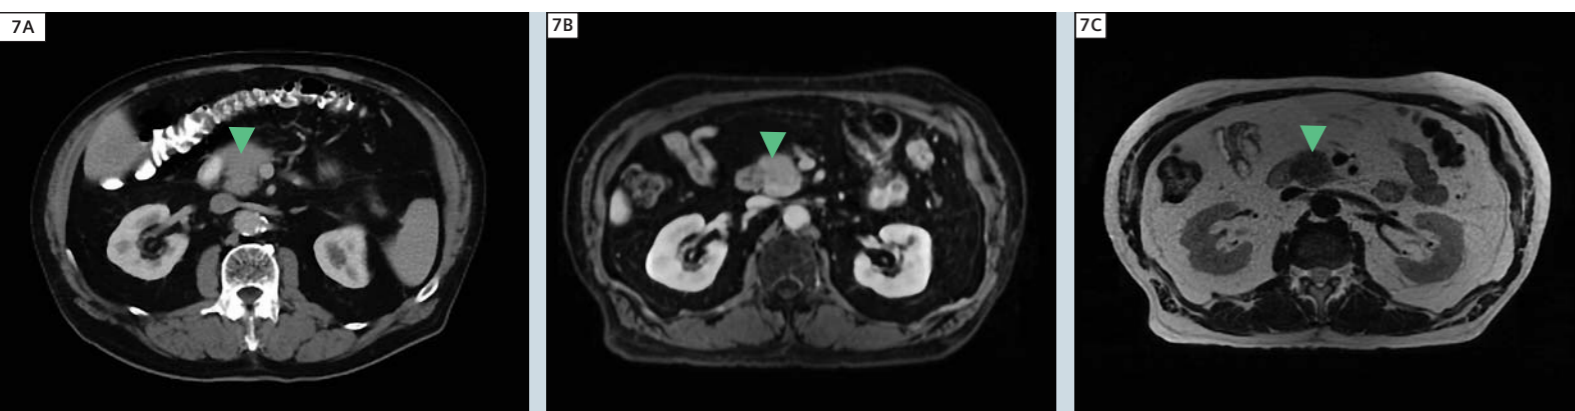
shows a venous phase contrast CT, venous phase contrast T1w and T2w MRI for the first carcinoma case in which a lesion in the head of the pancreas is hypodense in CT and hypointense in both T1w and T2w MRI. Also note the dilated pancreatic duct (DP). The ADC, and *f*-map for this case, presented in figure 3, clearly show the lesion as an area of low apparent diffusion on the ADC and hypo-perfusion (hypointense)
